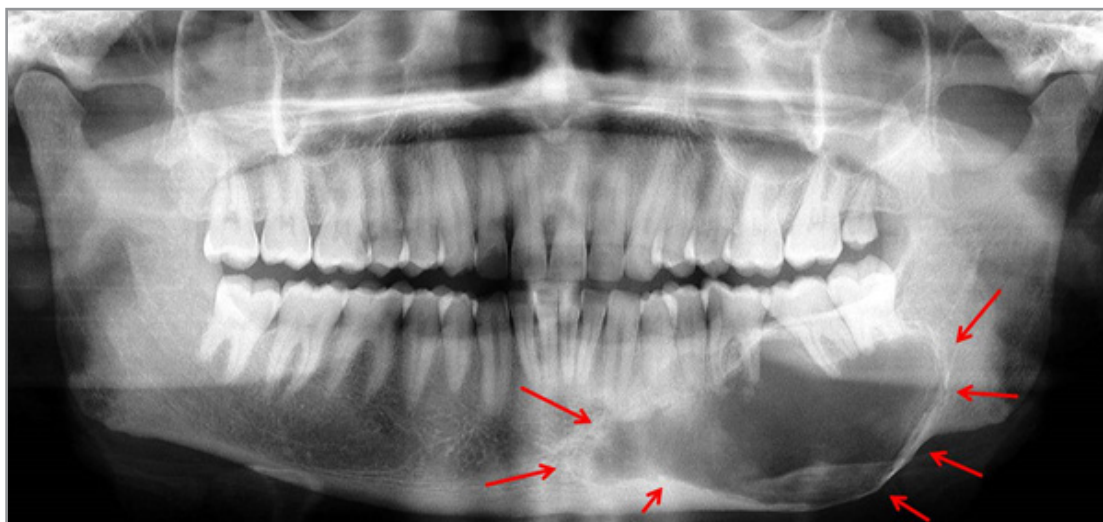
Orthopantomograph Radiograph Showing A Huge Unicystic Ameloblastoma In the Left Posterior Region of The Mandible (Red Arrows).
